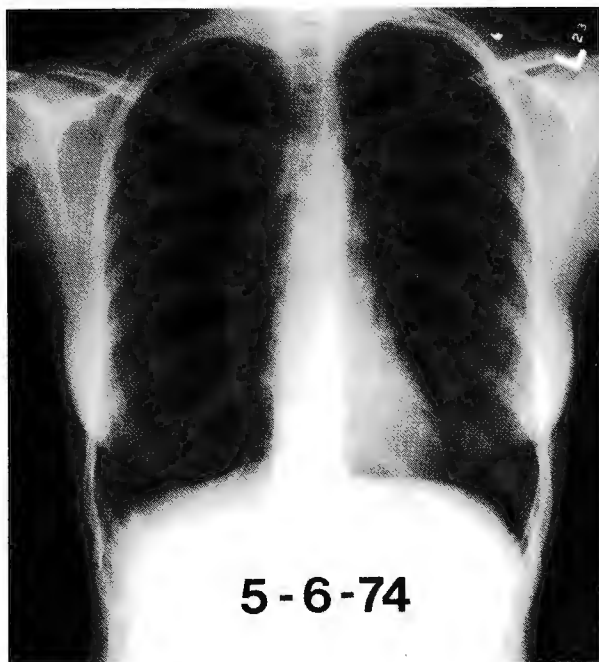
Posteroanterior chest roentgenogram of case 1 showing faint reticular densities in all lung fields and increased subcardiac air.
